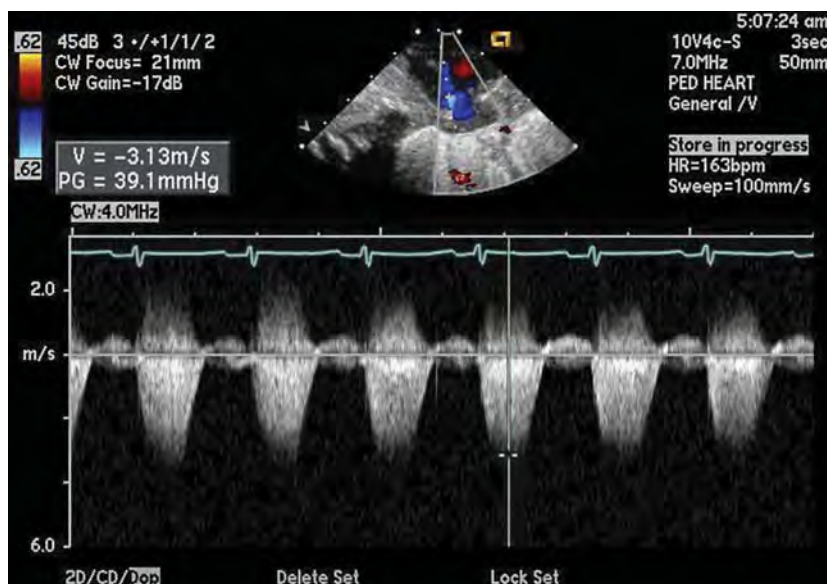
Parasternal long axis medially angulated tricuspid regurgitation Doppler pattern demonstrating elevated right ventricle and pulmonary artery systolic pressure.
